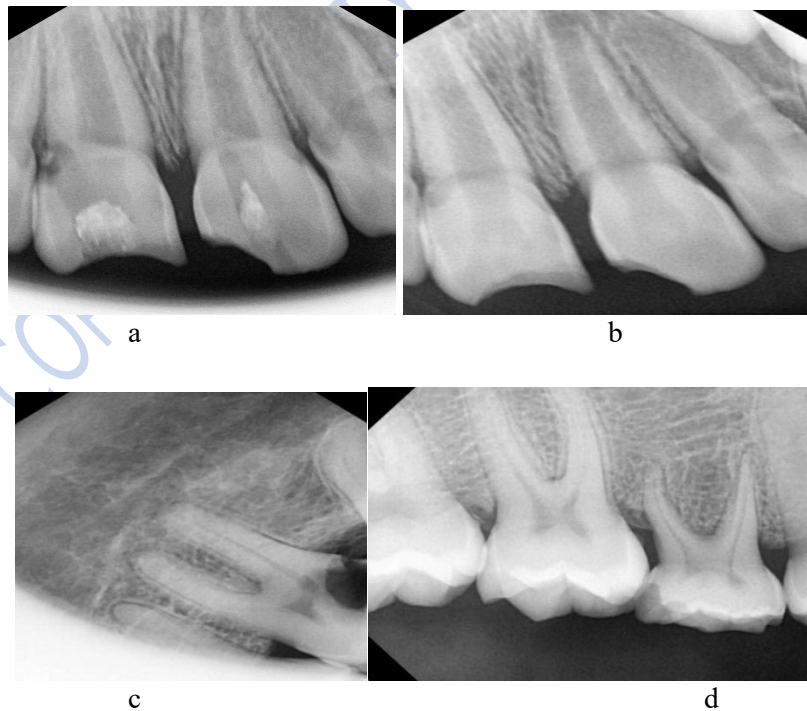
Dental images of Digital Radiographs
